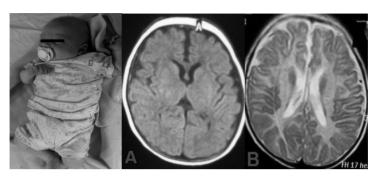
A four-month-old girl with MSUD, who was referred to our neurometabolic clinic due to hypotonia, irritability, spasticity, and seizures. Axial FLAIR MRI shows mild generalized cerebral atrophy (A). Axial T2W MRI indicates the same finding, as well as delayed myelination with white matter (WM) edema (B).
